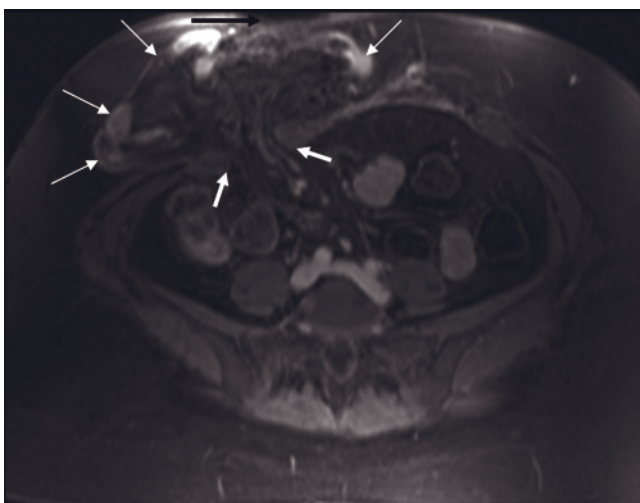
Spigelian hernia. Gadolinium-enhanced T1-weighted SGE image (a) in a patient with spigelian hernia. A bowel-containing hernia sac (arrowheads, a) protrudes through a defect in the aponeurosis between the transversus and rectus muscles (solid arrows, a). The lateral margin of the hernia sac is the intact external oblique muscle and fascia (open arrow, a). Transverse immediate postgadolinium T1-weighted SGE image (b) in a second patient. A spigelian hernia with protrusion of bowel contents (arrow, b) is noted in the right anterior abdomen.
